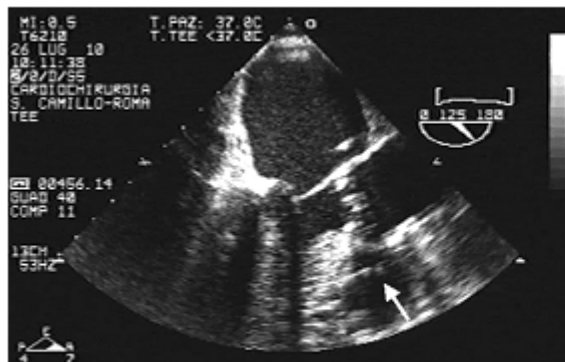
Intraoperative transesophageal echocardiography (TEE): valvuloplasty catheter impinging on the interventricular septum (white arrow).
